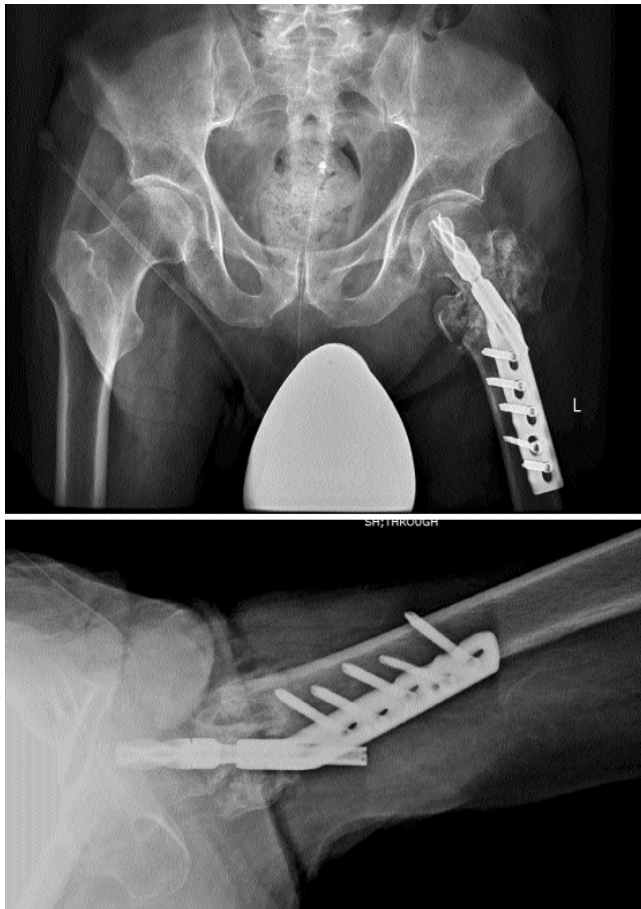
X-rays of fracture fixed with Spiral blade dynamic hip screw 4 months postoperatively.
